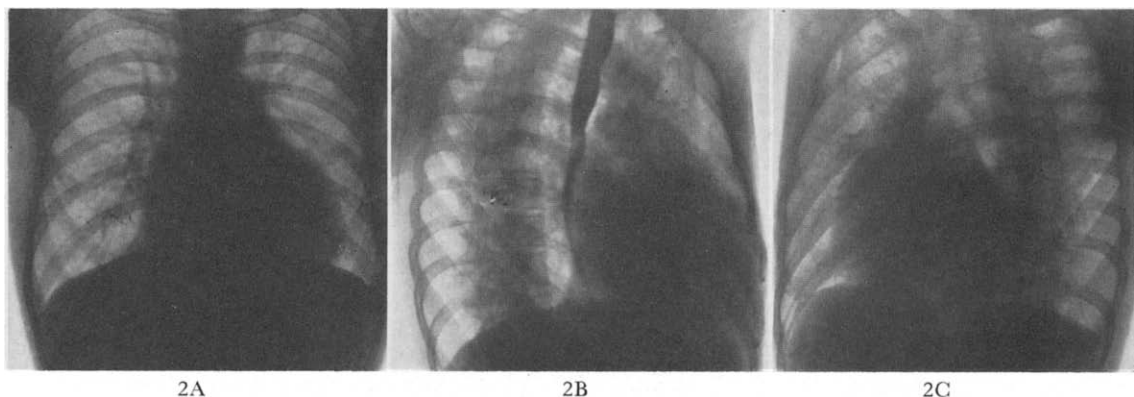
A, chest x-ray in posteroanterior position, indicating cardiac enlargement and pulmonary plethora. There is prominence of the aortic knob, pulmonary trunk and lower left contour. B, in the right anterior oblique position, the right ventricular enlargement is evident. C, in the left anterior oblique position, the left ventricular border is well over the spine, indicating enlargement of that chamber.
